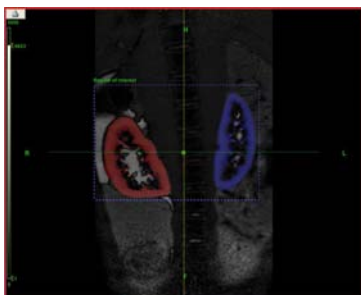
Example of segmentation of cortex based on the non-contrast MRI approach.
